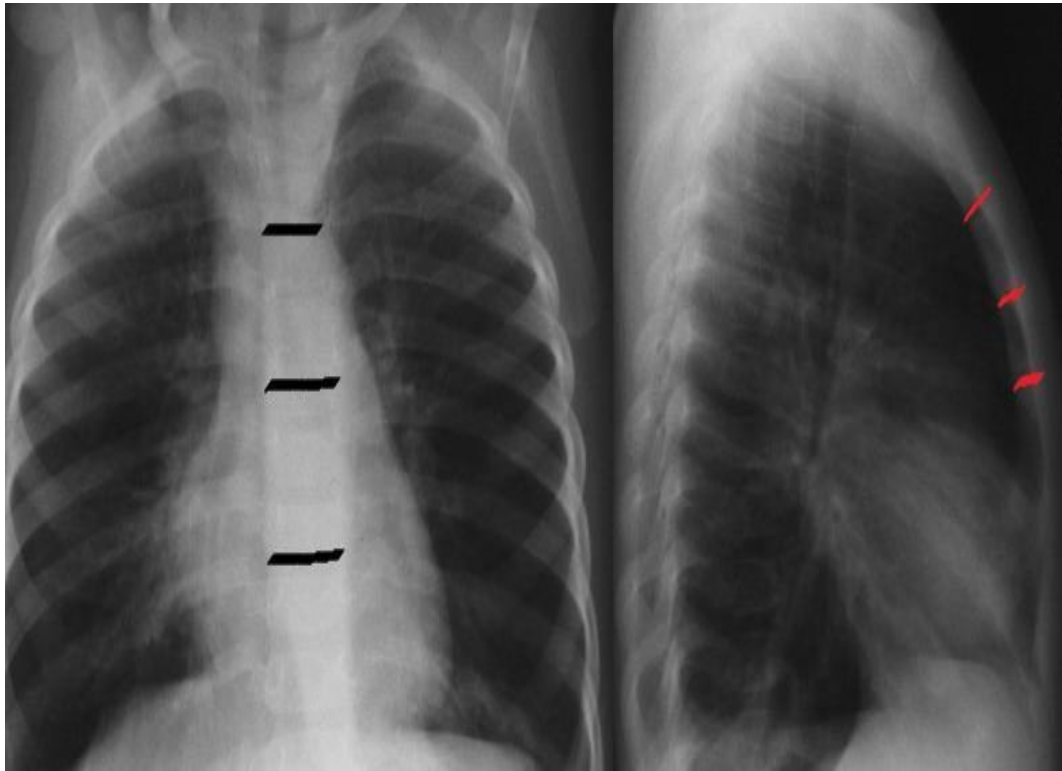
Preoperative chest radiographs (posteroanterior and lateral views) showing measurement of sternal width (PA view, black horizontal line) and sternal thickness (lateral view, Red semi-vertical line).
